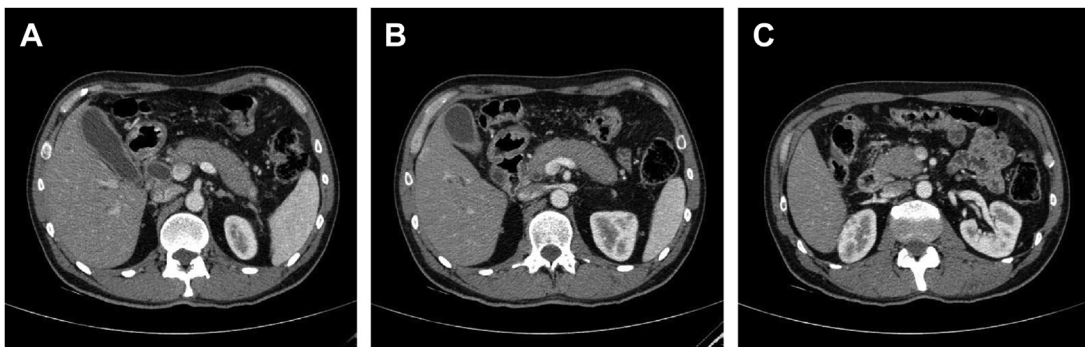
Computed tomographic (CT) images showing (A) pancreatic, (B) biliary, and (C) renal involvement in type 1 AIP.
